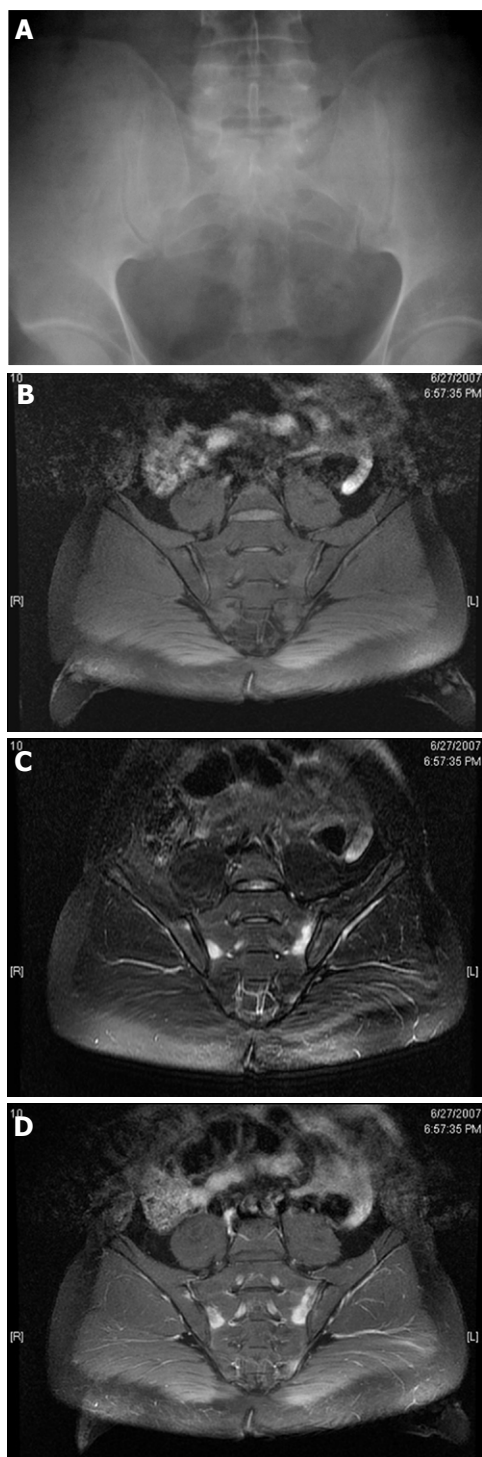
Normal radiograph of the pelvis and early changes on sacroiliac magnetic resonance imaging of a male patient at the early stages of the disease at the pre-radiographic stage. A: Thirty-five year old male, normal anterior posterior pelvis radiograph; B: T1-weighted Fast Spin Echo semi-oblique coronal scans of the sacroiliac joints; C: T2-weighted fat suppressed images shows bone edema at both sacral and iliac bones; D: T1-weighted post-contrast image shows enhancement of the contrast media revealing acute inflammation.
